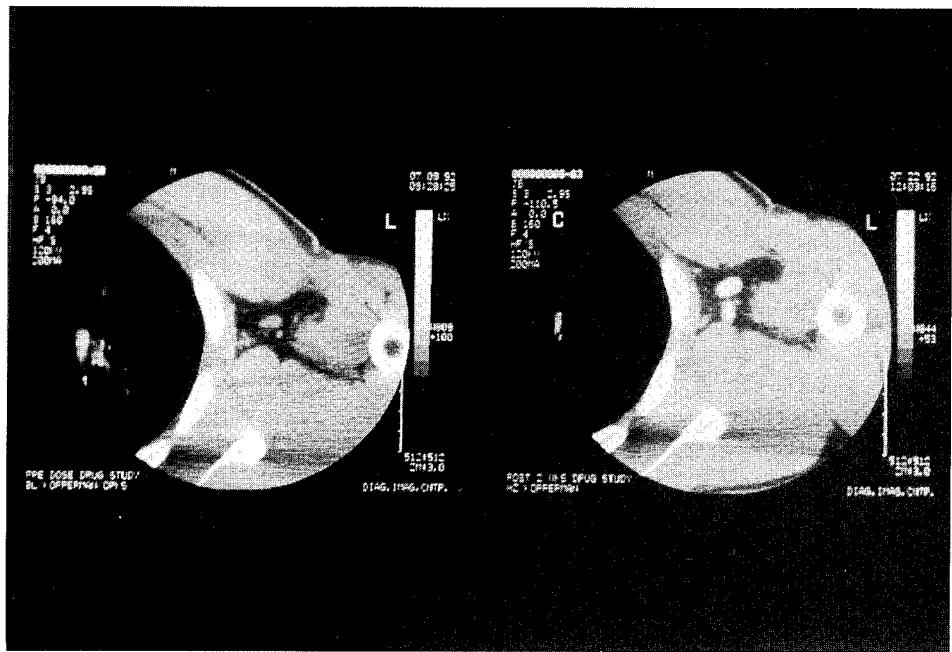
CT image of enhanced human axillary lymph nodes following subcutaneous injection of 4.0 mL perflubron emulsion dose in the hand. Left: preinjection; right: 14 days postinjection (120 kV, 200 mA, 3 mm contiguous slice).
